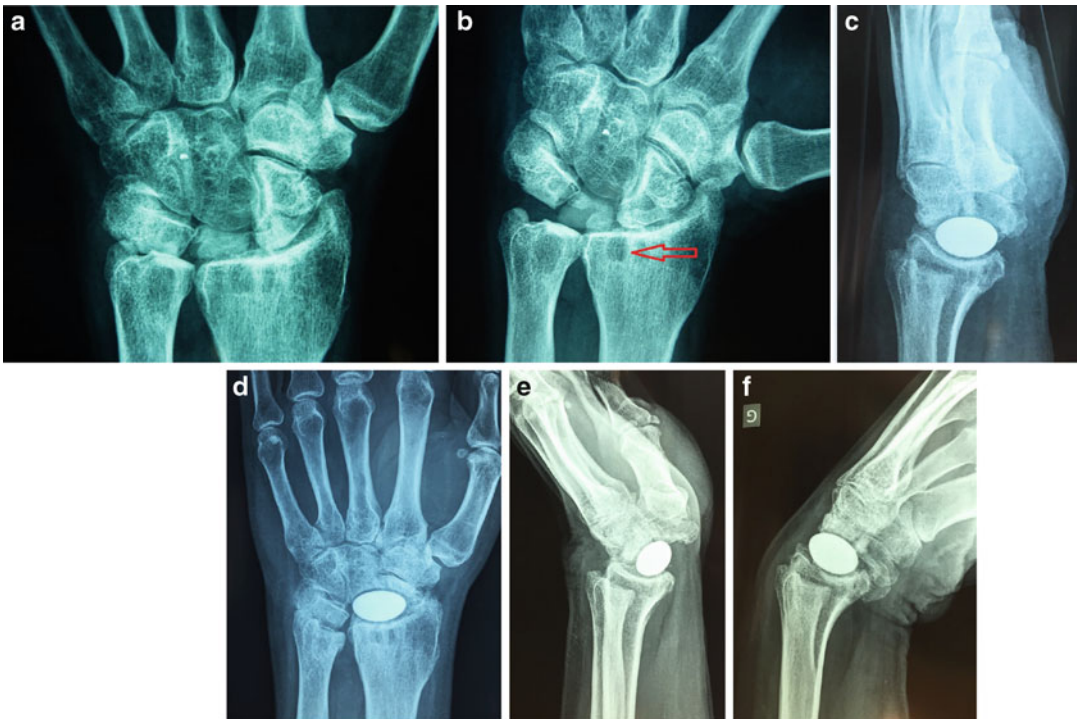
Silicone lunate implant inserted in 1992 for Kienböck’s disease stage 3. Patients represent with pain and stiffness in 2009. (a) AP radiograph with silicone implant. (b) AP radiograph with radial inclination. *Red arrow*
